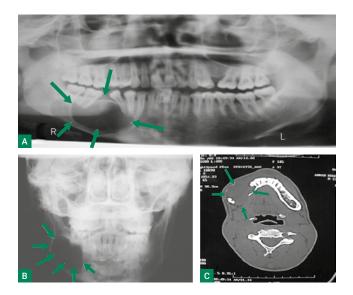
Displays ameloblastoma variant type. A & C: OPG and MRI showing uninoculated radiolucency with smooth borders and displacement of teeth. B: a radiolucent area in the right angle of mandible. (Al-Salihi K A, Ihsan Abdullah, Ling Yoke Li Clinico-radiologic features of four cases of Ameloblastoma. Brazilian Journal of Oral Sciences. 2018; 17:e18028. http://dx.doi.org/10.20396/bjos.v17i0.8651903).
